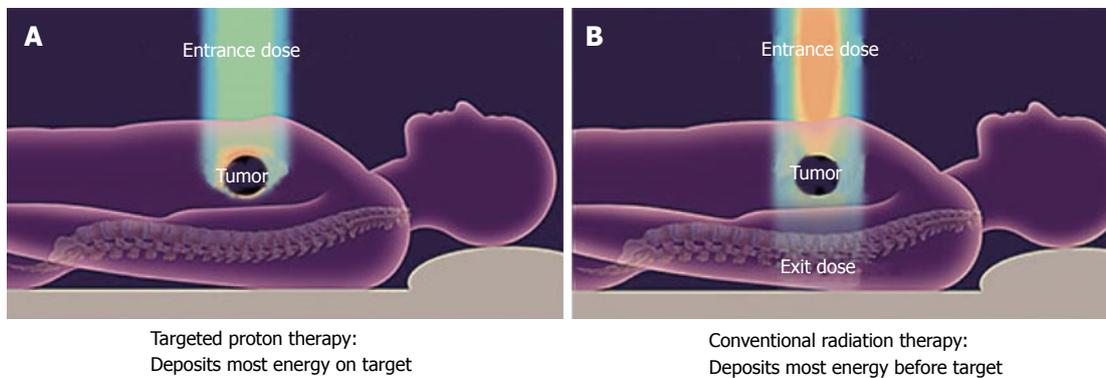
With X-rays, the tumor dose is significantly less than the entry dose and exit dose is delivered beyond the tumor target. With conventional radiotherapy (A) using X-rays (photons), the highest dose is near the point of beam entry into the patient. The tumor dose is significantly less than the entry dose. Also, an exit dose is delivered beyond the tumor target. With protons (B) and other particle therapies, such as carbon ions, the entry dose is low. The highest dose is at the depth of the tumor target and there is no exit dose beyond the target. Image borrowed from the University of Florida Health Proton Therapy Institute.
